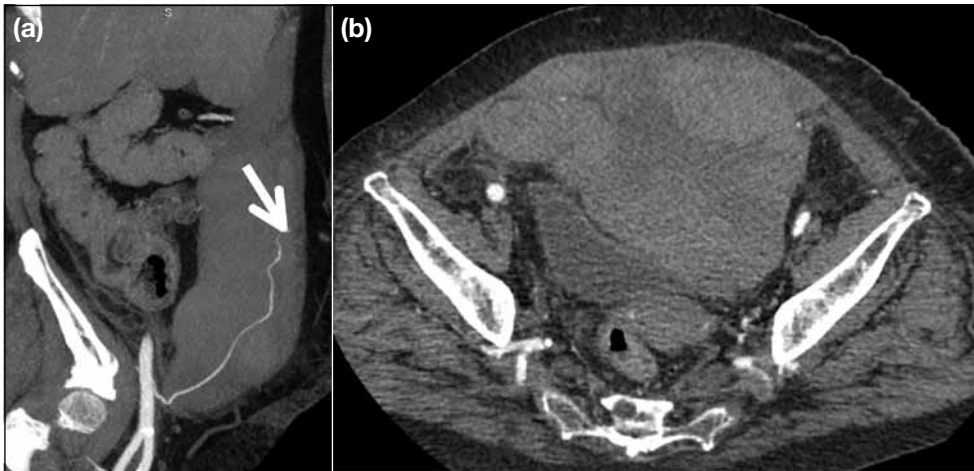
(a) Coronal and (b) axial reformatted maximum intensity projection images of contrast-enhanced computed tomography in the arterial phase showing a type-III rectus sheath haematoma crossing the midline with posterior extension to the pelvic preperitoneal space and minimal contrast extravasation from the right inferior epigastric artery (arrow).
